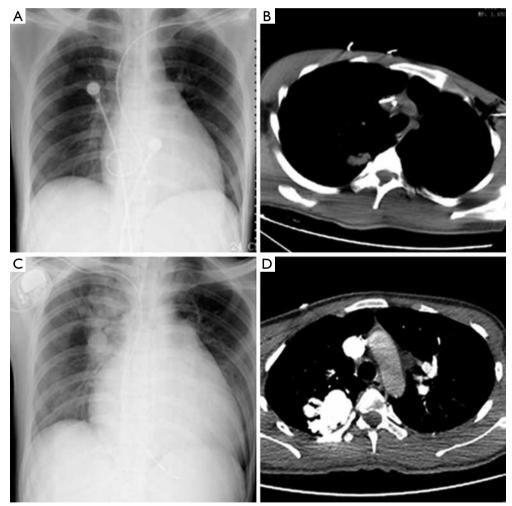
Imaging findings of a 22-year-old young man with pulmonary arteriovenous malformations. (A) Thoracic X-ray revealing no nodule for the first admission; (B) thoracic CT revealing right upper lobe pneumonia; (C) thoracic X-ray revealing nodules at the both pulmonary hilus and upper lobe of the right lung for the last admission; (D) contrast-enhanced CT revealing a large nodular lesion suggestive of pulmonary arteriovenous malformations at right upper lobe. CT, computed tomography.
